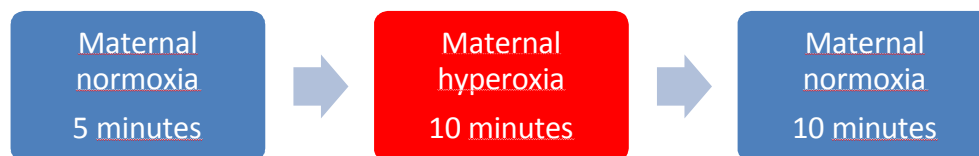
The maternal oxygen supply during the BOLD MRI scan in the human fetal study.
